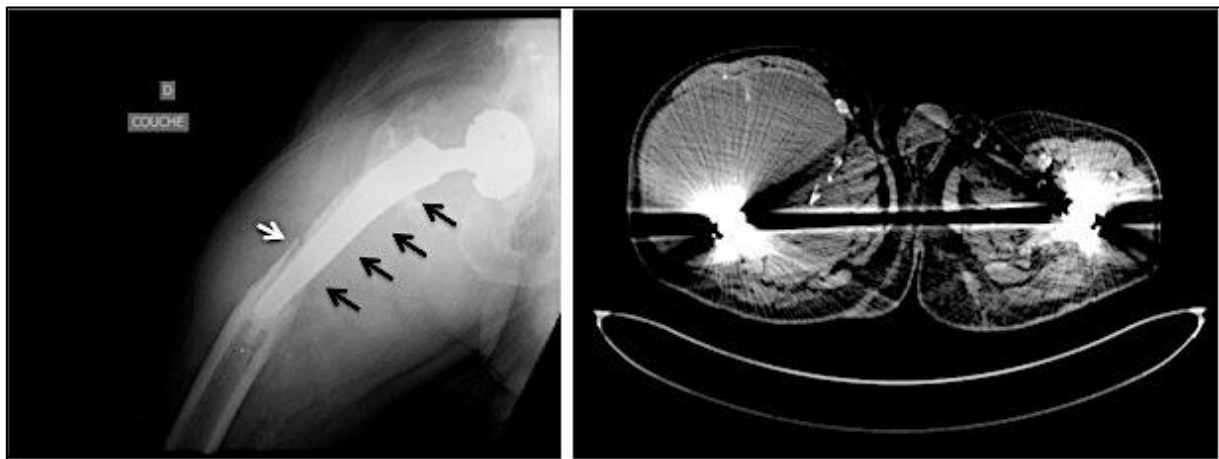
Antero-posterior view of X-Ray (left side) and axial view of computed tomography (right side) of right metal-on-metal THA revised by pseudotumour with extensive osteolysis in medial cortical femora (black arrows) after 96 months of survival in 83-year-old male patient. Pathological fracture was observed in lateral cortical femora (white arrow).
